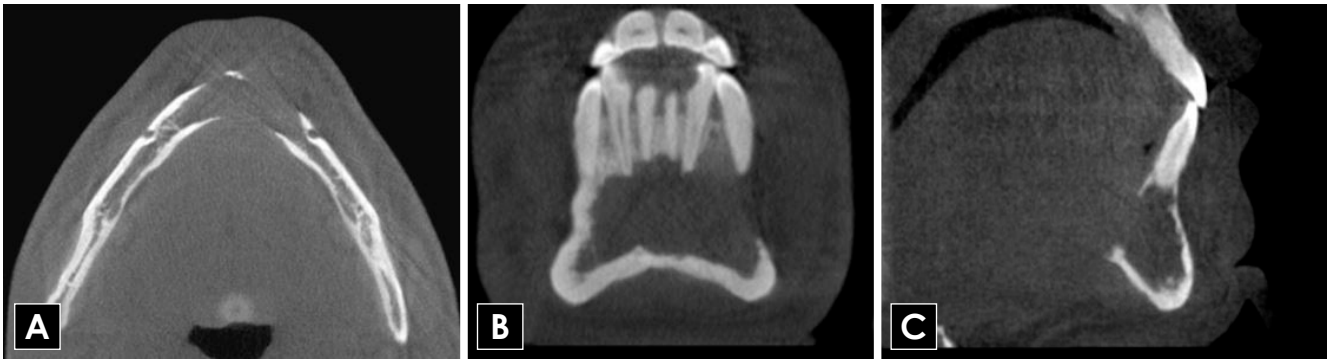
Axial (A), coronal (B), and sagittal (C) CBCT images indicate a unilocular low-density lesion without apparent expansion involving the anterior region of the mandible. CBCT: cone-beam computed tomography.
